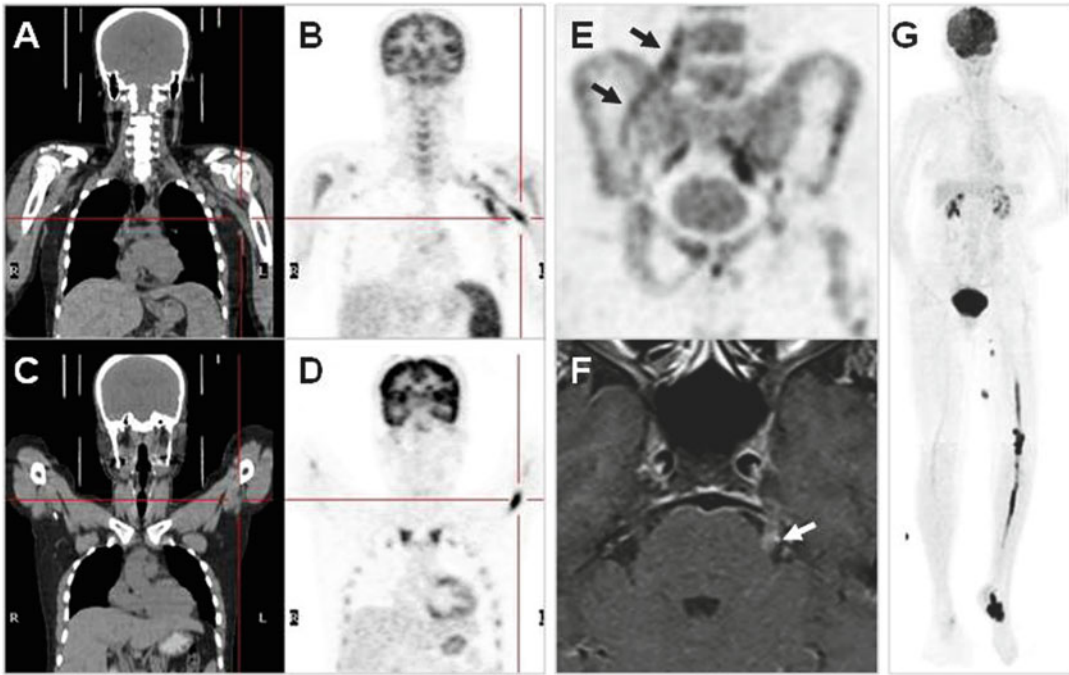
Imaging in neurolymphomatosis (a and b) Increased uptake of the FDG tracer is demonstrated on the left brachial plexus (b) with localization co registered on the CT (a). The abnormal tracer uptake indicates that the neural structure is infiltrated by a previously diagnosed and treated lymphoma. (c and d) Left radial nerve involvement demonstrated by FDG-PET (b) with localization co registered on the CT (c) in a patient with a previous diagnosis of non-Hodgkin lymphoma. (e) FGD-PET imaging of the same patient as in c and d demonstrating an increased tracer uptake in the region of the right lumbosacral plexus. Multifocal infiltration
